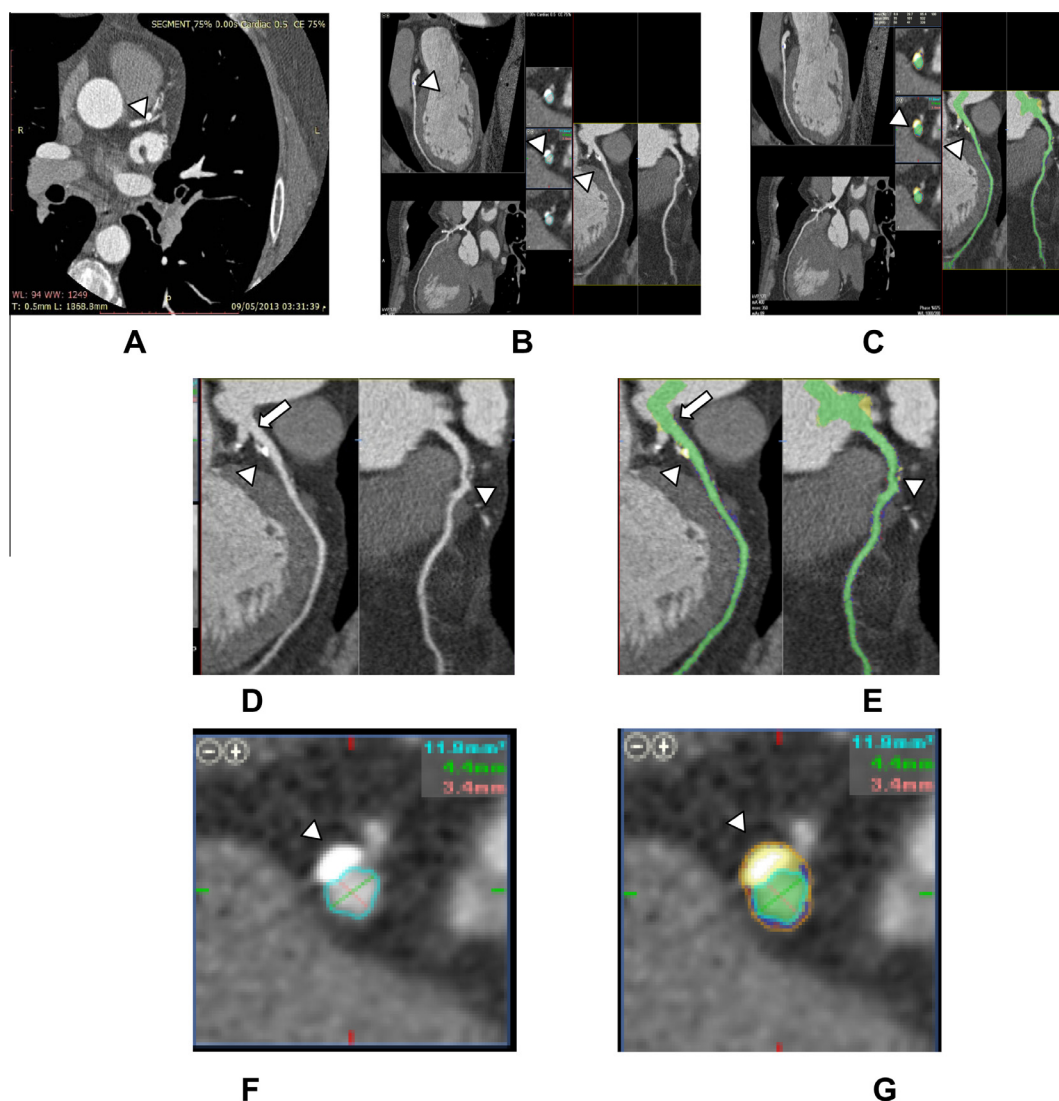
A male patient, 58 years old, with controlled diabetes, came for check up for atypical chest pain. (A) Contrast-enhanced 64 multi-detector row cross sectional CT image: average caliber LAD is seen arising from LM demonstrating an eccentric mixed plaque, predominantly of calcific component at its mid portion causing no significant stenosis. The plaque measures 5.7 mm in length and 1.4 mm in width (white arrowhead). (B&C) Grey scale and colored curved MPR images respectively of left anterior descending artery (LAD) show a single eccentric predominantly calcific plaque causing positive remodeling (as shown by white arrowhead). Note the lumen is patent with no plaque encroachment upon the lumen. (D&E) Magnified MPR image grey scale and colored images respectively shows the +ve remodeling as shown by white arrowhead. The calcified component is yellow colored while the scanty soft tissue component is blue colored. Note the reference segment is free of plaques (white arrow). (F and G) A colored cross-sectional image at site of positive remodeling (white arrowhead) showing the calcified component of the plaque (yellow colored). The calculated remodeling index = 1.72.
